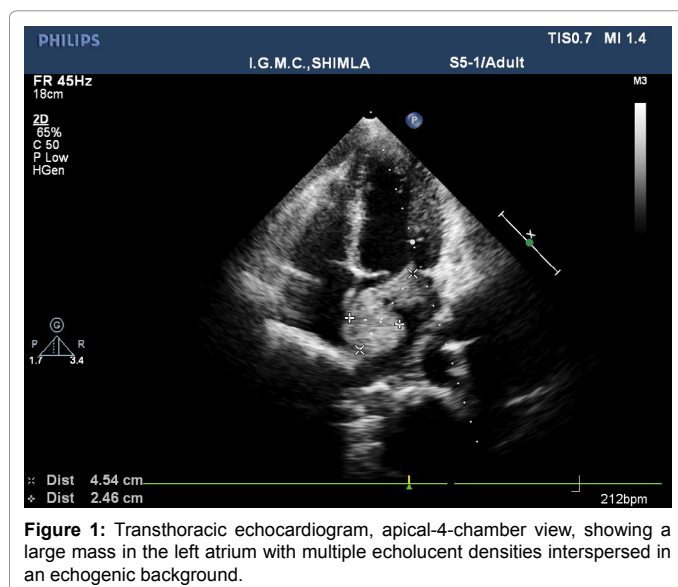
Transthoracic echocardiogram, apical-4-chamber view, showing a large mass in the left atrium with multiple echolucent densities interspersed in an echogenic background.
